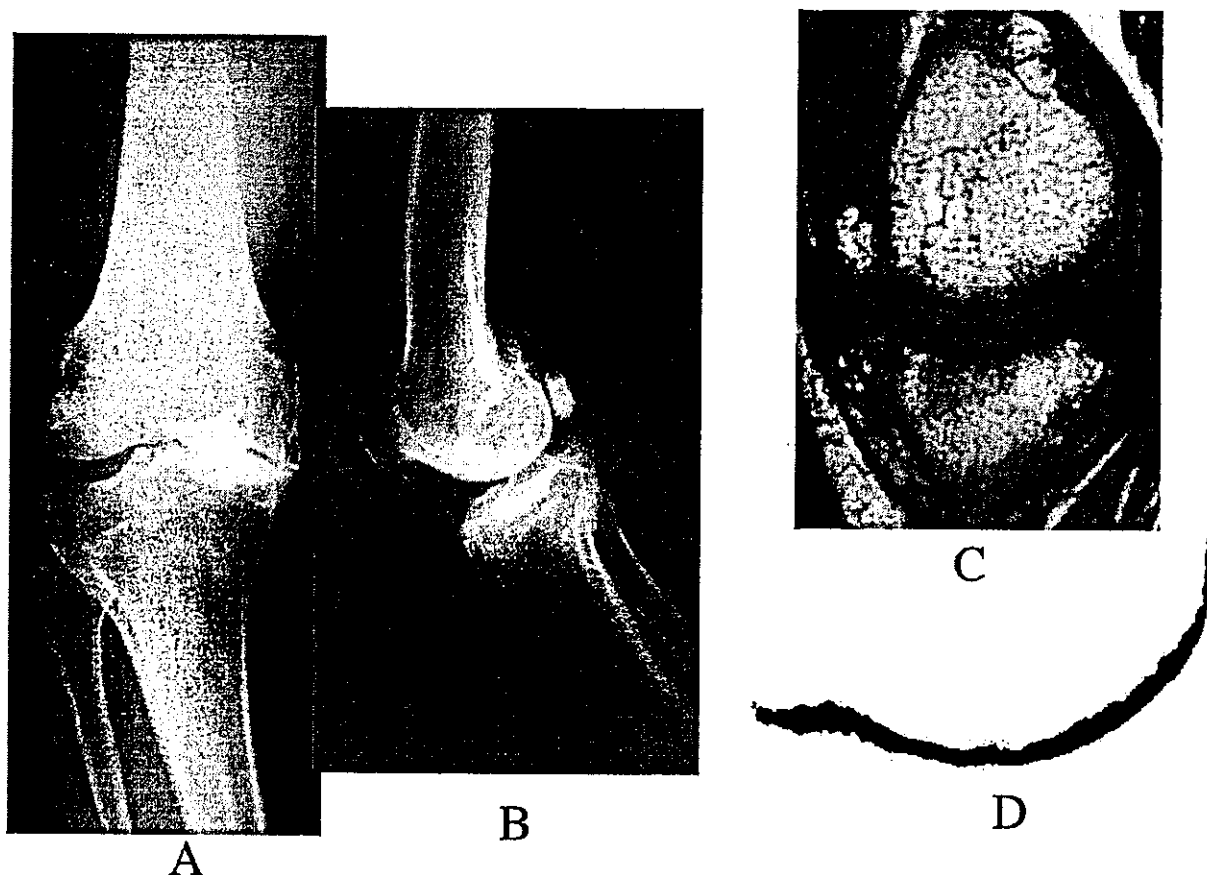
Case 1: A 76-year-old man with varus deformity of  $7^\circ$  was treated with arthroscopic PMR. (A) Standing anteroposterior radiograph showed a highly reduced joint space in his medial compartment. (B) Lateral radiograph showed slight arthritic changes in the patellofemoral (PF) joint. (C, D) MRI showed minimal irregularity in terms of the contour of the medial femoral condyle.
